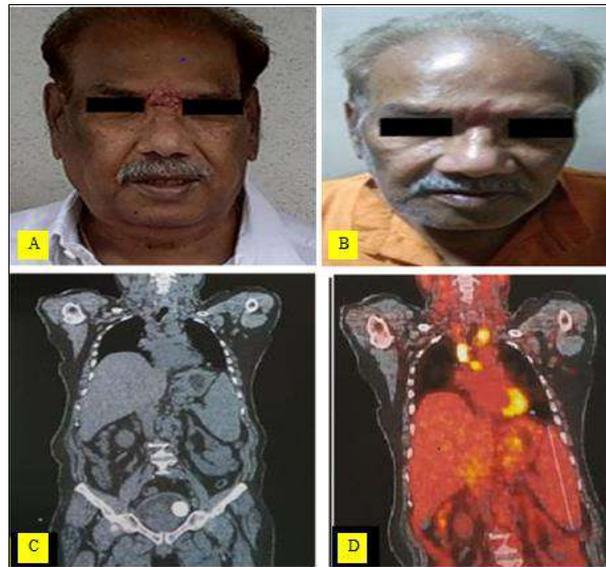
A: painless erythematous papules and nodules over the forehead (at presentation). 1-B: Post treatment photograph with resolution of the skin lesions. 1-C&D: F18- FDG Whole body PET scan shows multiple hyper metabolic enlarged lymph node.
